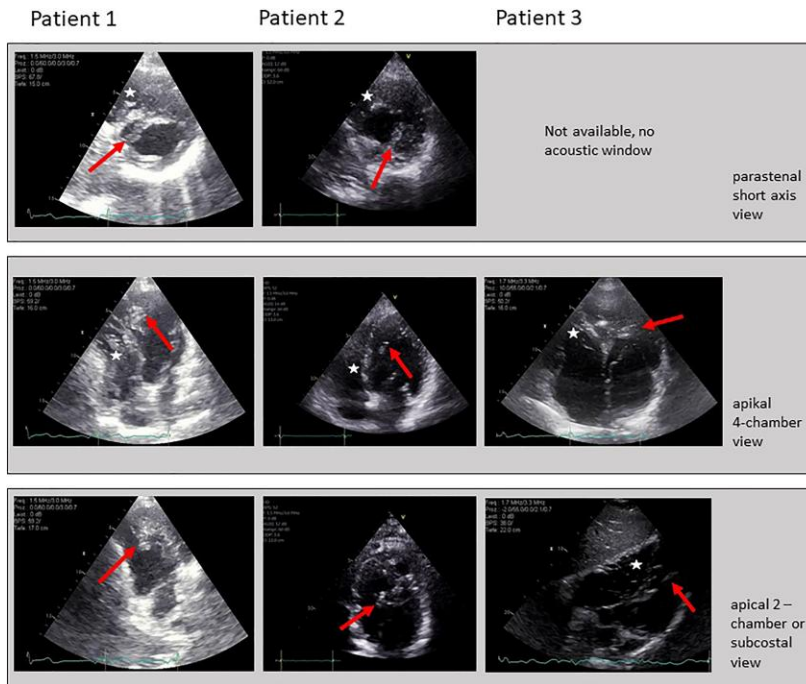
Presentation of double-chambered left ventricle in echocardiography. Arrow: additional left ventricle septum; Star: right ventricle cavity.
